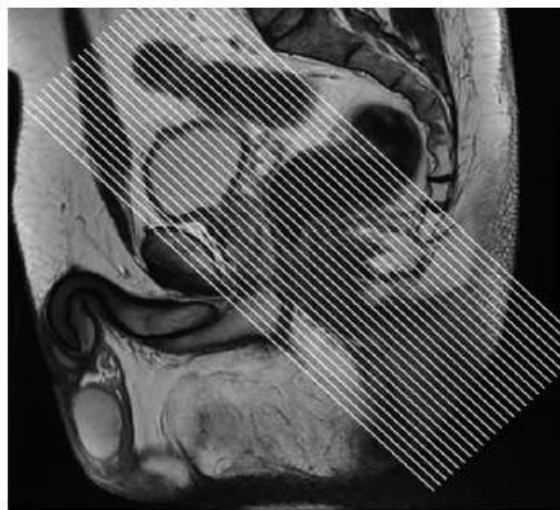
Suggested orientation for coronal MR imaging of the anal canal. Coronal MR imaging is performed at 90° relative to the axial plane to obtain images parallel to the long axis of the anal canal.
